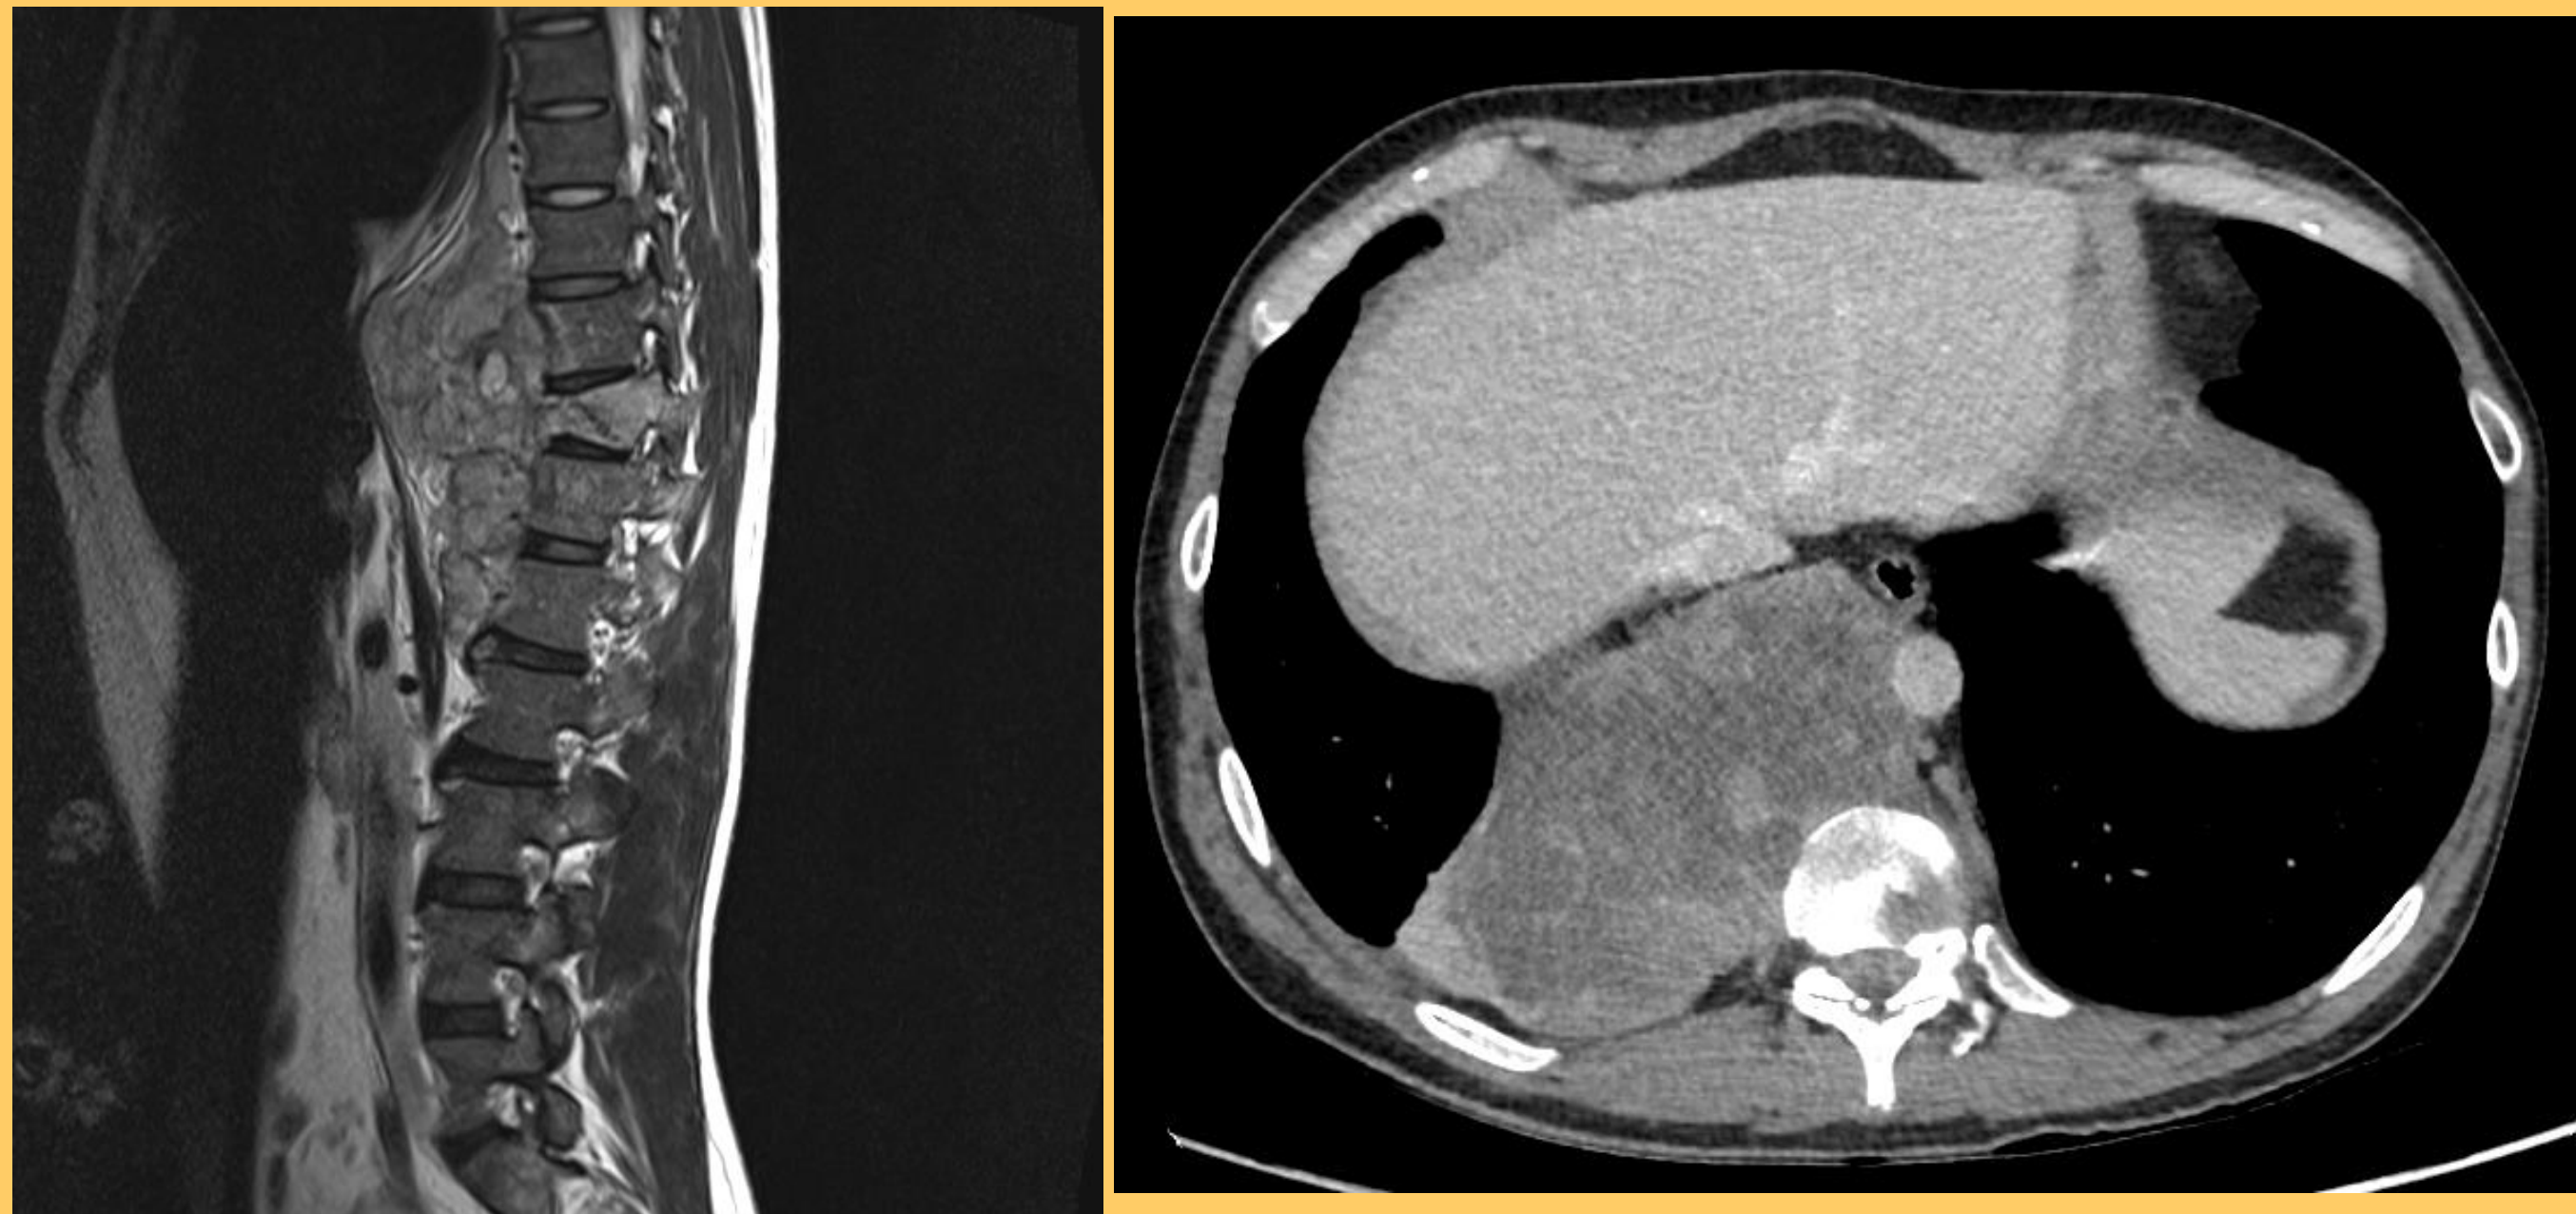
MRI September 2020
